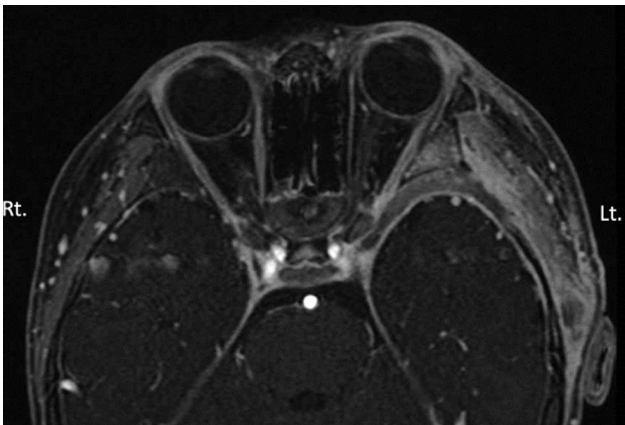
Postoperative magnetic resonance imaging (MRI) shows the total tumor removal.
